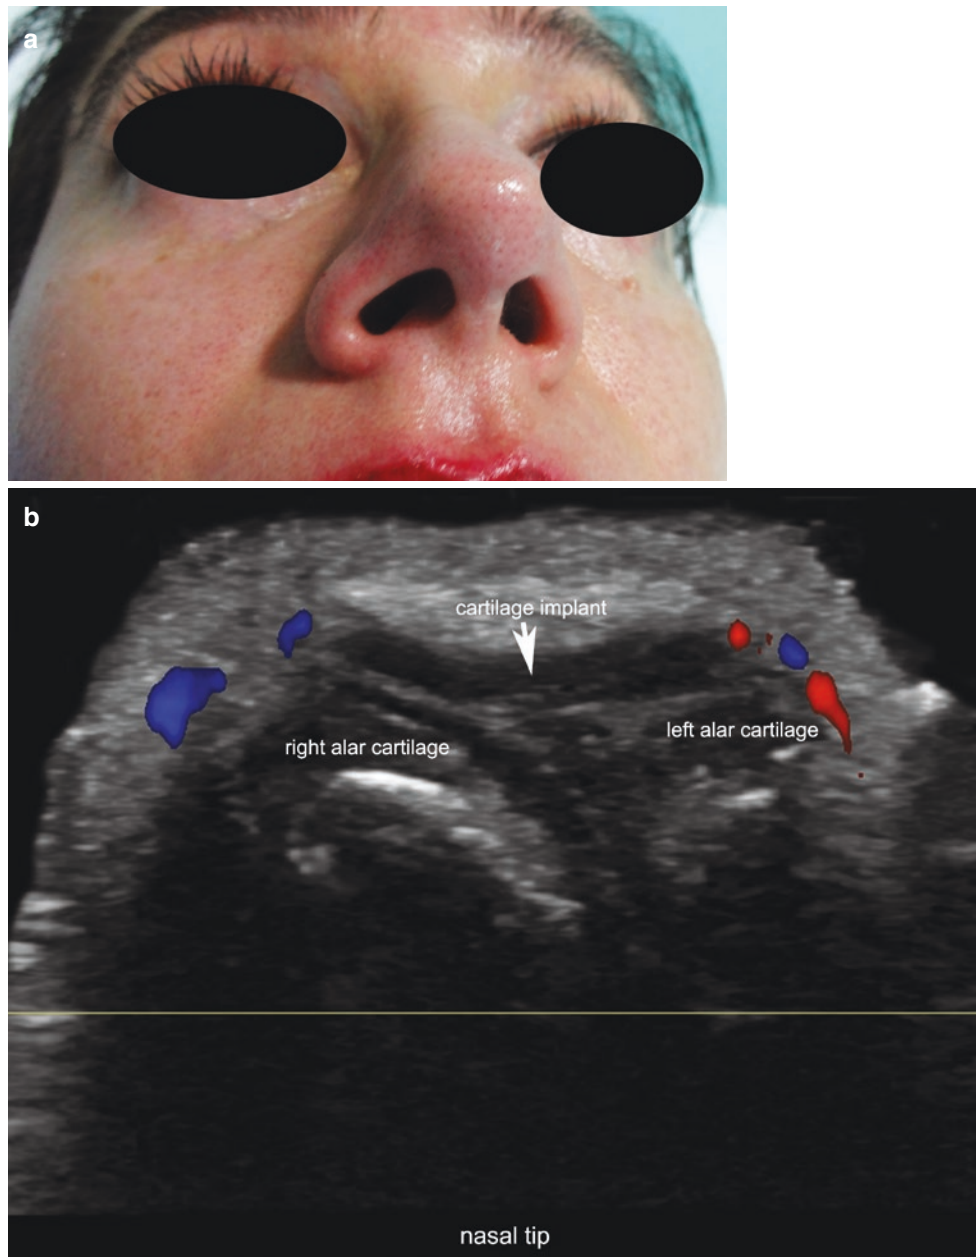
Cartilage implant. (a) Clinical image of a patient with a history of cartilage implant in the tip of the nose. (b) Color Doppler ultrasound (transverse view; tip of the nose) demonstrates a hypoechoic
